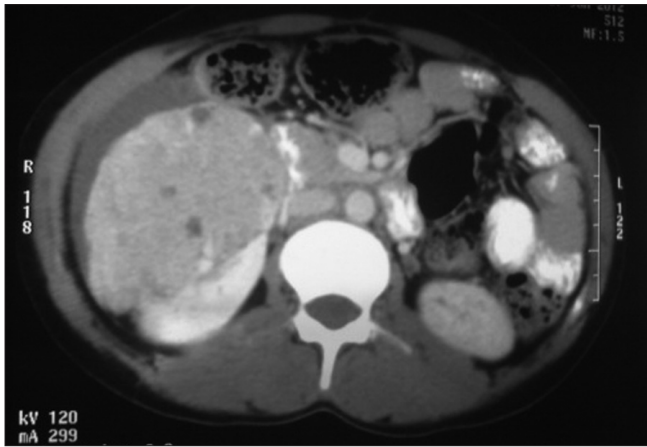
CT scan - A well defined heterogeneously enhancing mass lesion with areas of hypodensities
